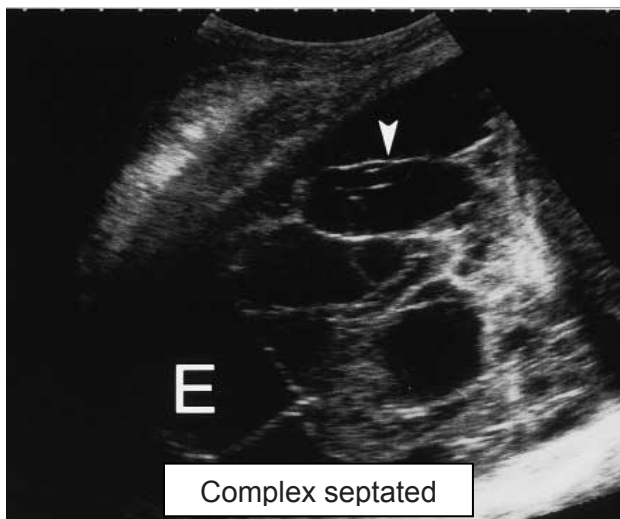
Thoracic ultrasound showing complex pleural effusion along with septation (arrowhead)
